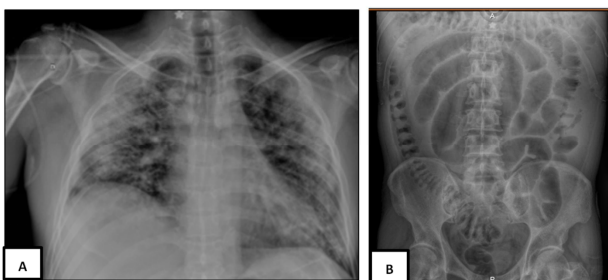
A) Anteroposterior chest X-ray/plain abdominal X-ray in standing position.
